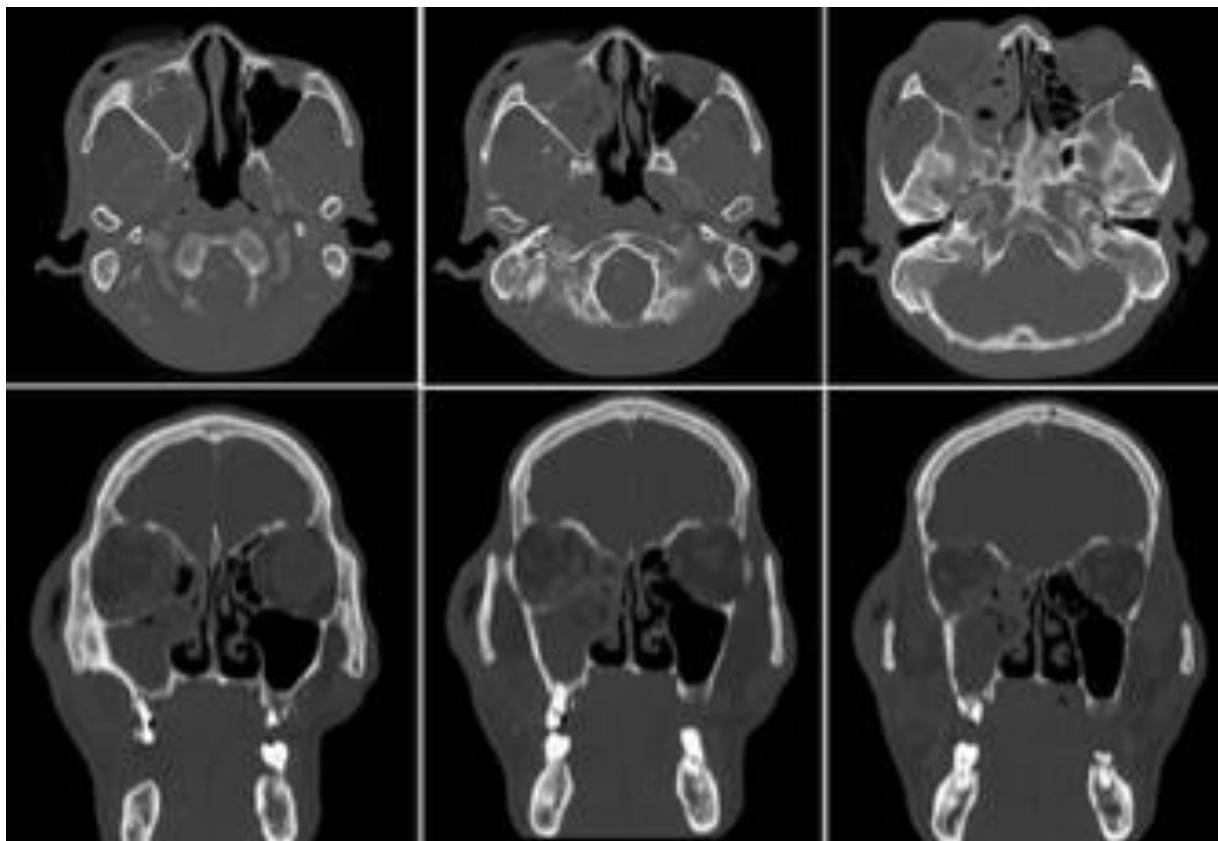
CT-scan of paranasal sinuses.
